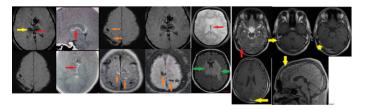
loss of flow void in dural venous sinuses on T2-weighted (T2W)&fluid-attenuated inversion recovery (FLAIR) images with hyperintense signal on T1W images (Figure 1,2).
